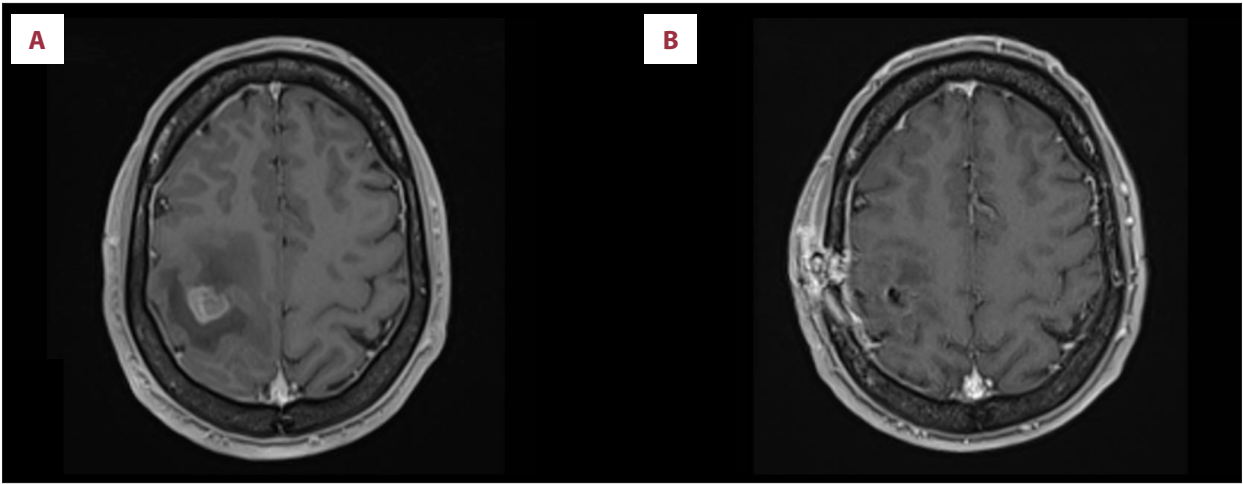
(A) Preoperative T1-weighted brain MRI with gadolinium contrast: single intraparenchymal tissue lesion on the right central region, with clear vasogenic edema reaction with a suspected secondary origin. (B) Postoperative T1- weighted brain MRI with gadolinium contrast: post-surgical remodeling with no signs of recurrence. MRI, magnetic resonance imaging.
